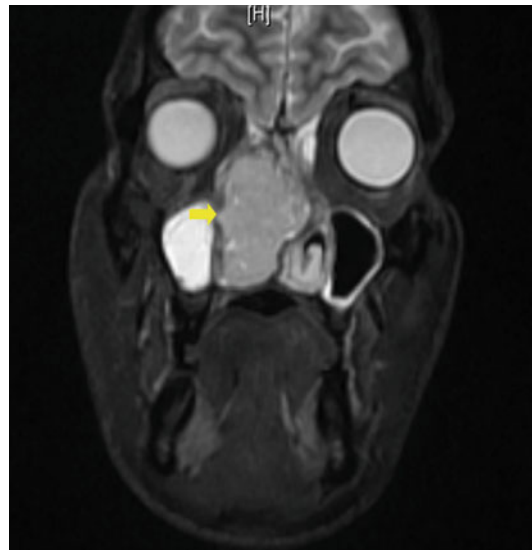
Coronal T2 MRI image of paranasal sinuses showing tumor in the right nasal cavity with retained secretions in the right maxillary sinus (yellow arrow)
